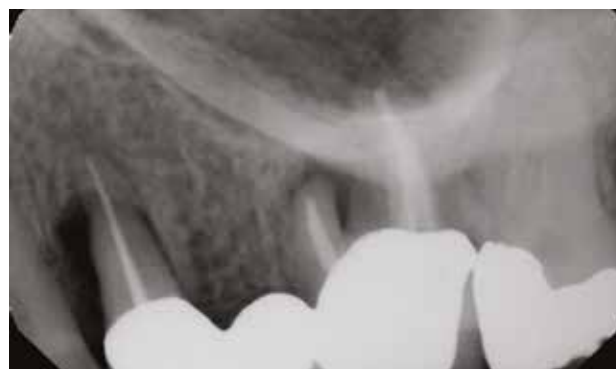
Periapical radiograph demonstrating failed endodontics with associated osseous destruction that will necessitate extraction of the bridge abutment teeth.
